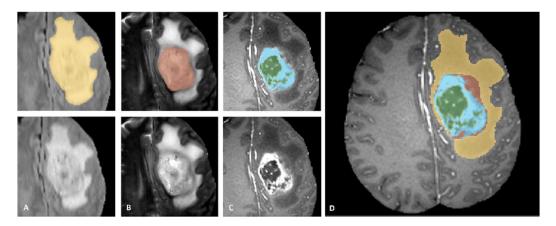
"Manual annotation through expert raters. Shown are image patches with the tumor structures that are annotated in the different modalities (top left) and the final labels for the whole dataset (right). Image patches show from left to right: the whole tumor visible in FLAIR (A), the tumor core visible in T2 (B), the enhancing tumor structures visible in T1c (blue), surrounding the cystic/necrotic components of the core (green) (C). Segmentations are combined to generate the final labels of the tumor structures (D): edema (yellow), non-enhancing solid core (red), necrotic/cystic core (green), enhancing core (blue)." Figure and Description taken from: [8]
